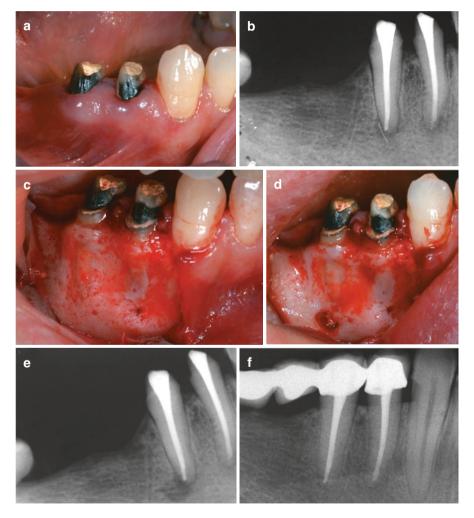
(a, b) Preoperative clinical and radiographic image of a mandibular premolar with a fragment extruded in the periapical area. (c) Flap retraction and exposure of the buccal bone with the perforation of the area with the fragment. Retrieval of the fragment. No resection of dental tissues was needed. (d) Immediate postoperative radiograph. (e) Follow-up post-restoration radiograph (Courtesy of Dr. C. Boutsioukis and Prof. I. Lavrentiadis) (with permission from Lambrianidis et al. 2007)
